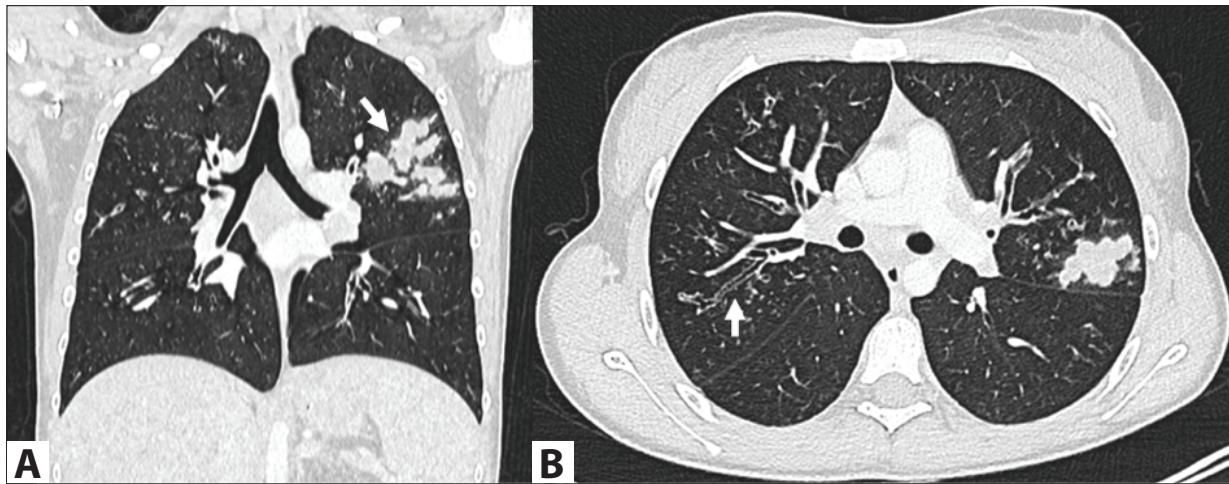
Coronal reformat CT (A) in the parenchymal window and axial plan thorax CT (B) through the upper lobes showing bronchi filled with mucus plugs (white arrow, A), thickening of bronchial walls (white arrow, B) and centrilobular nodular opacities.
